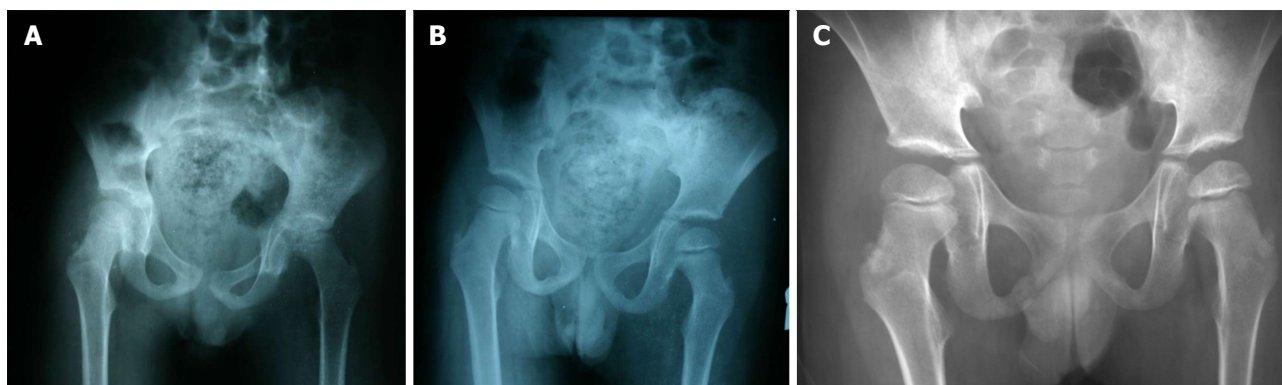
Plain radiographs of the pelvis both hip joints for a 4-year-old boy; the right hip joint was dislocated after minor trauma. A: Notice the neck-shaft angle; B: A radiograph was taken one week after closed reduction shows the stable reduction; C: A radiograph was taken after three years of reduction shows no signs of avascular necrosis.
